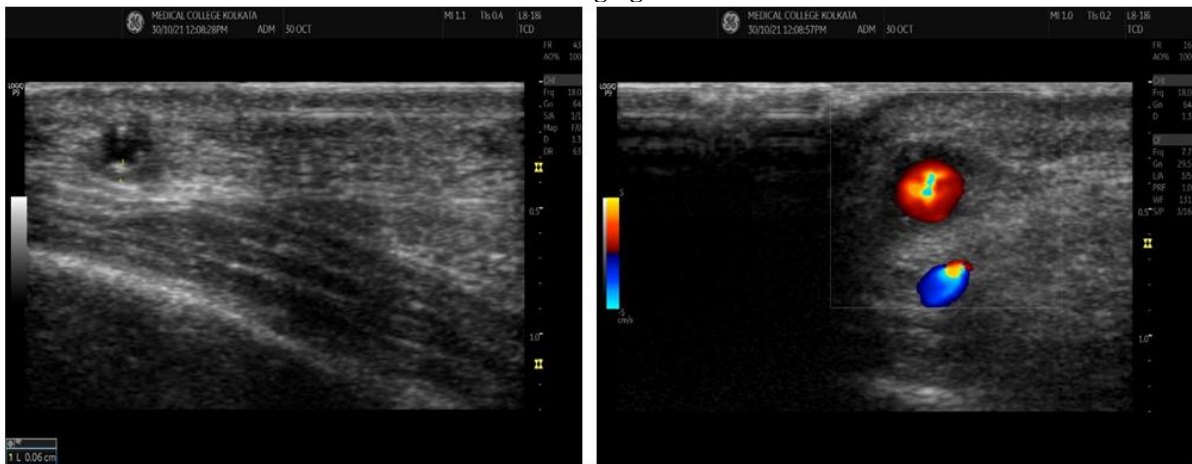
A 53-year-old male presented with severe throbbing headache more on right side. B mode showed increased diameter of the common superficial temporal artery. Colour doppler shows hypoechoic wall thickening characteristic of halo sign. Halo score was calculated to be 21 in this patient.
